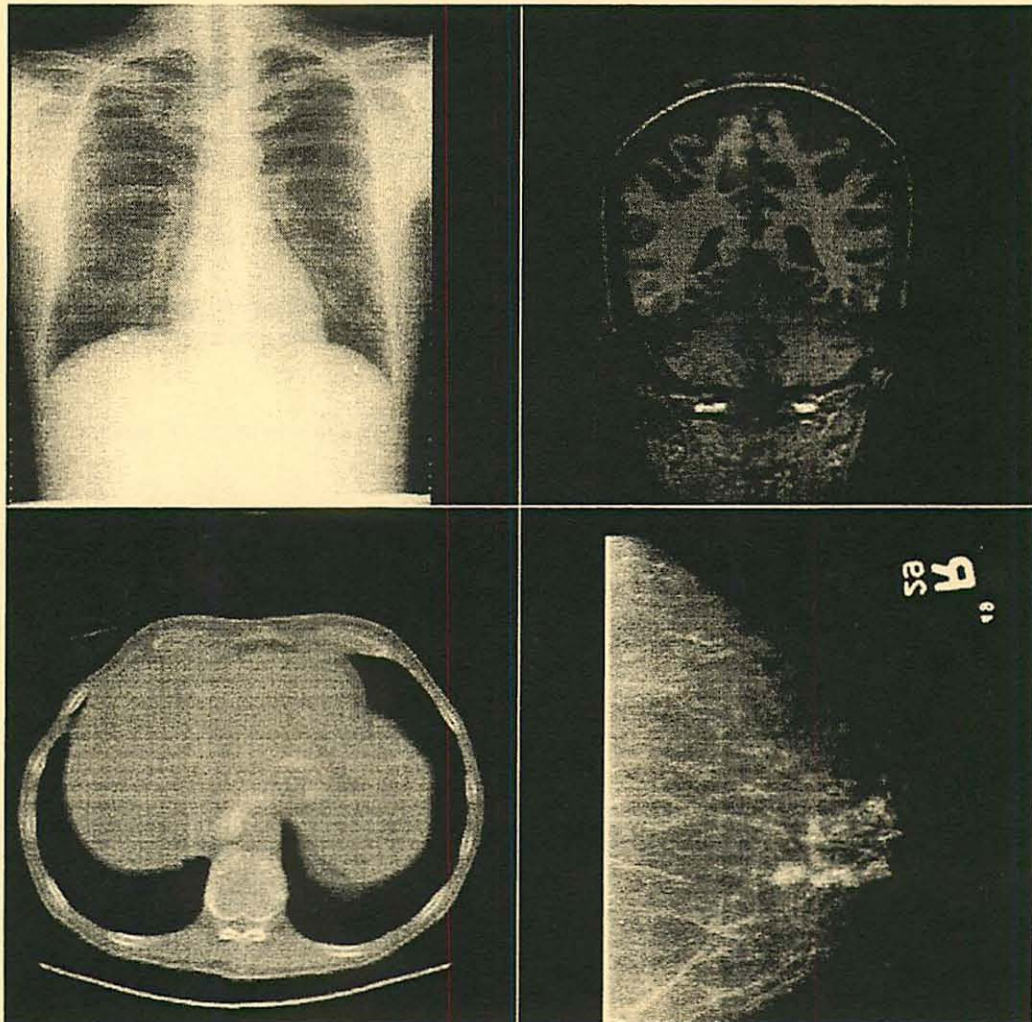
Typical images in our experiment. Clockwise from upper left corner: Chest CR, Head MRI, Mammogram, and Abdominal CT.
